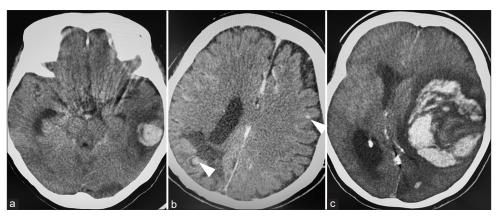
Time course of head CT scan after endovascular parent artery occlusion. On postoperative day 3 (day 57), head CT showed left temporal lobe subcortical hemorrhage (a) on day 85, head contrast-enhanced CT showed multiple microaneurysms (arrow heads) (b) on day 92, head CT showed left putamen hemorrhage with cerebral herniation (c).
